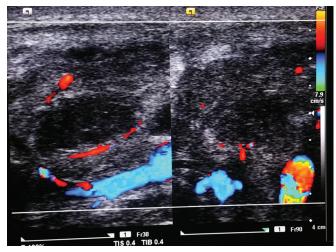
Color Doppler study showing enlarged lymph node with absent hilum and peripheral vascularity in longitudinal and transverse sections
